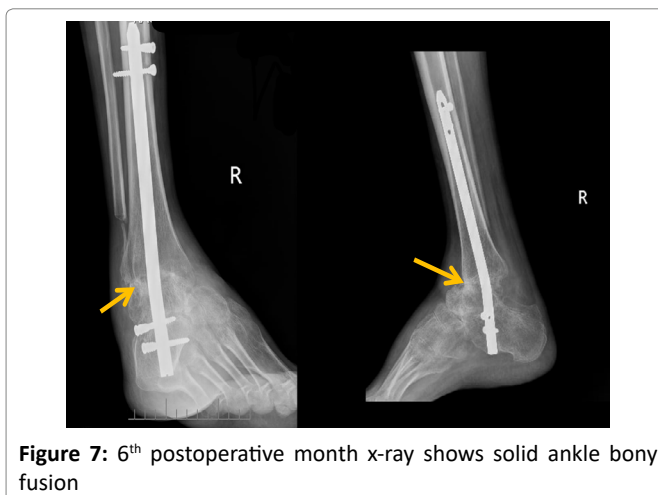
6th postoperative month x-ray shows solid ankle bony fusion
